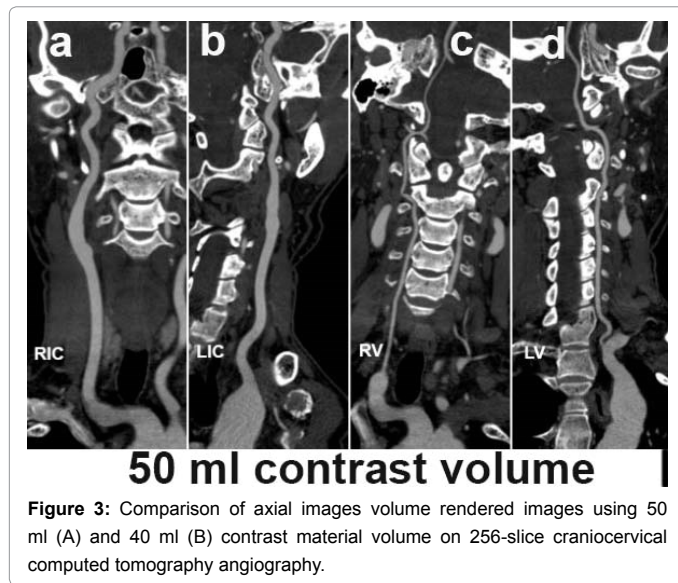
Comparison of axial images volume rendered images using 50 ml (A) and 40 ml (B) contrast material volume on 256-slice craniocervical computed tomography angiography.
